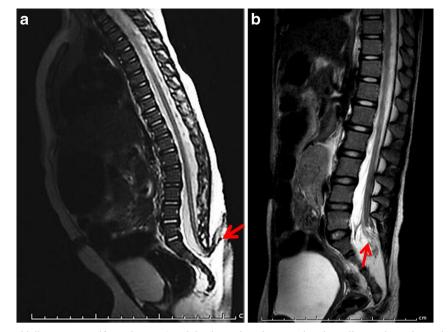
a, b Closed NTD with lipomatous malformation. a T2-weighted sagittal MRI of subcutaneous lipomatous tissue that extends into the low lying tethered spinal cord. In this case, neural tissue (*arrow*) and CSF extend beyond the spinal canal. This lesion could be termed a *lipomyelomeningocele*. Because the disordered embryogenesis, clinical manifestations, and prognosis for patients with this form of closed NTD differ considerably from those of patients with a myelomeningocele, it is better to refer to these lesions as lipomatous malformations to eliminate
